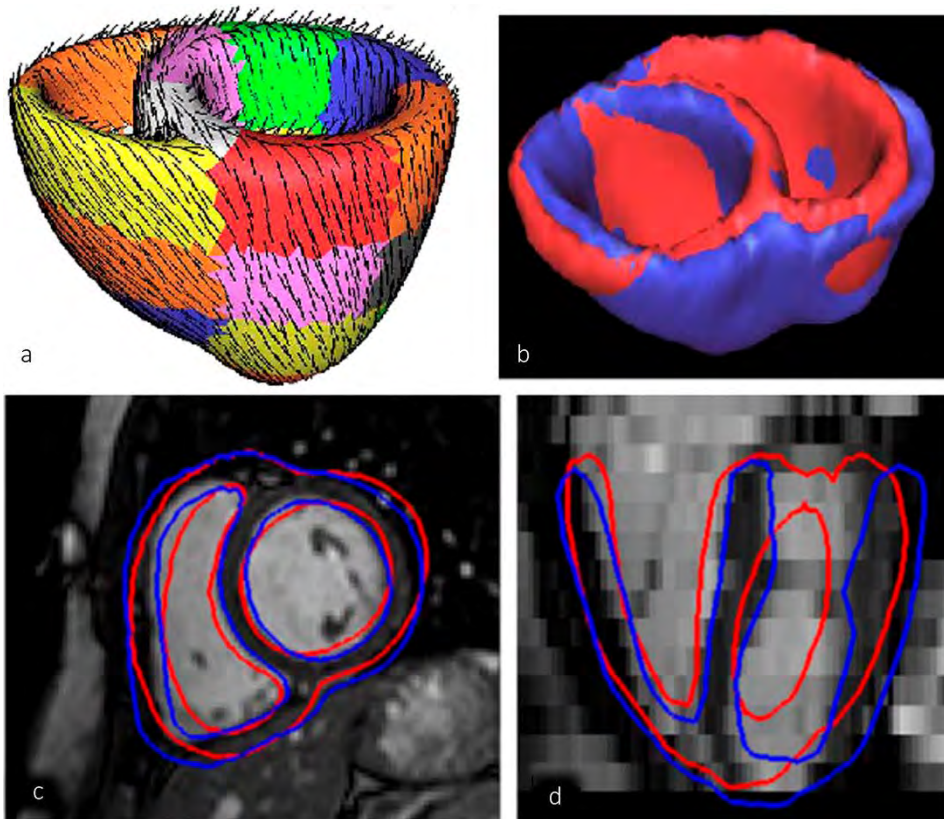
(a) Initial mesh (geometrical model based on ellipsoids) of a bi-ventricular deformable model for cardiac MRI segmentation, including cardiac fibre orientation (*black lines*) and AHA regions (*colour code*). (b) 3D surfaces of the model. MRI slices in the cardiac short-axis (c) and four-chambers plane (d), showing the contours before (*red*) and after (*blue*) the local deformation of the initial model mesh in order to match the patient-specific cardiac anatomy. Adapted from (Sermesant et al., 2006b)
